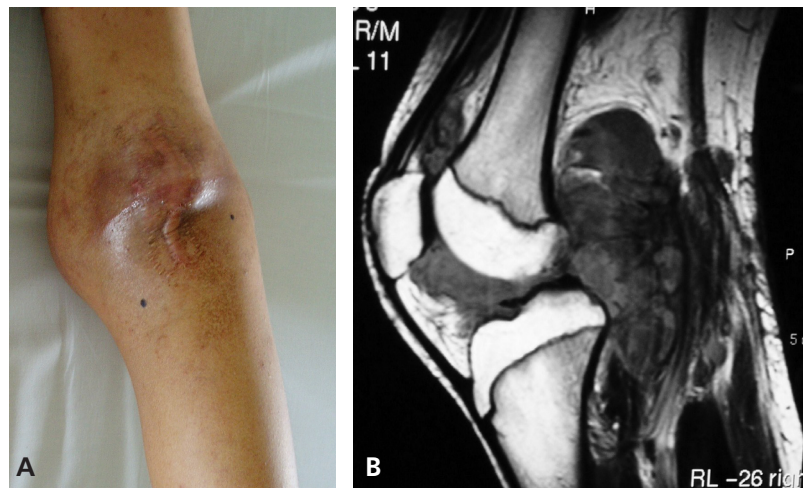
15-year-old male with popliteal swelling diagnosed initially as villonodular pigmented synovitis. 1A: Photograph of the swelling and scar from the initial surgery. 1B: MRI of the swelling.
